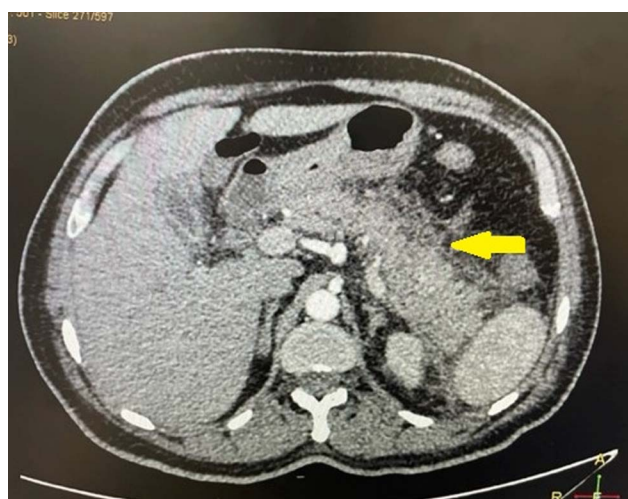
Abdominal contrast enhanced computed tomography showing a bulky pancreas with peripancreatic fat stranding (arrow).
